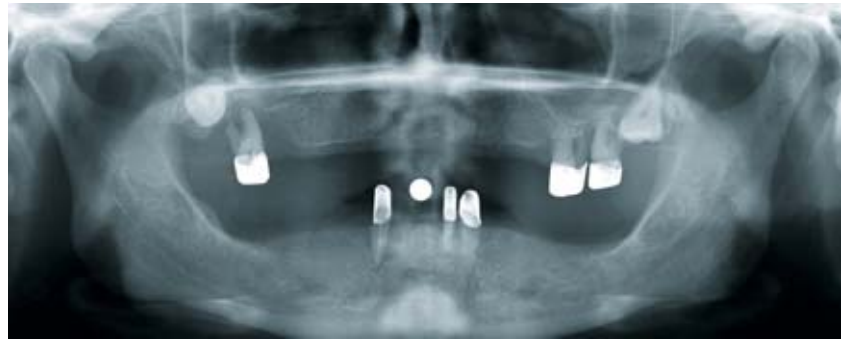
Pre-treatment standard radiograph
